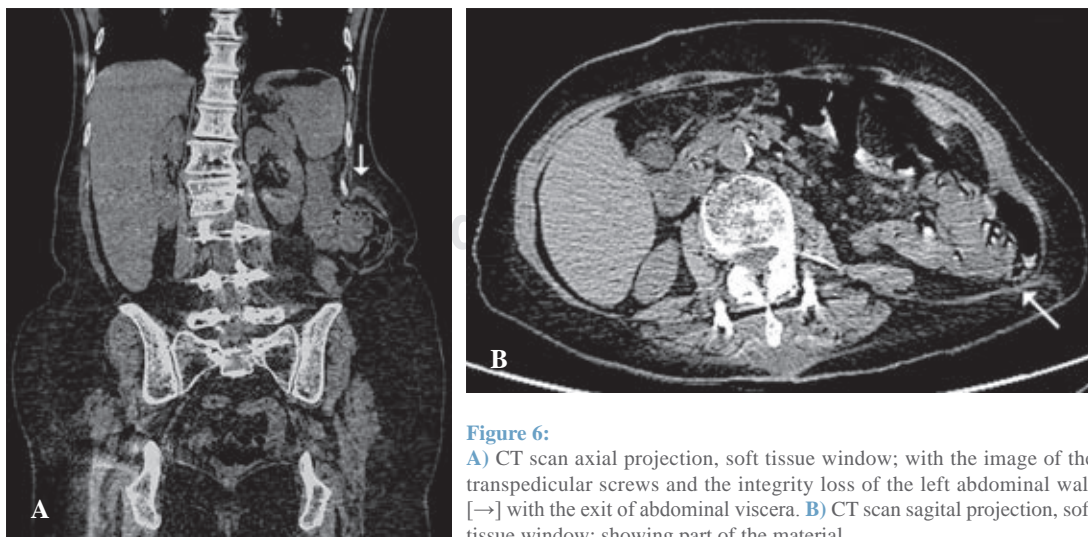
A) CT scan axial projection, soft tissue window; with the image of the transpedicular screws and the integrity loss of the left abdominal wall [→] with the exit of abdominal viscera. B) CT scan sagittal projection, soft tissue window; showing part of the material.
